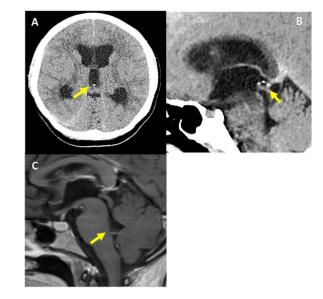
(A) CT scan (axial section) shows a cyst at the level of the third ventricle with central scolex; (B) CT scan (sagittal section) showing also the scolex at the level of the third ventricle; (C) MRI T1 post-gad (sagittal section) showing isodense cyst with CSF at the level of the fourth ventricle after placement of ventricular shunt.
